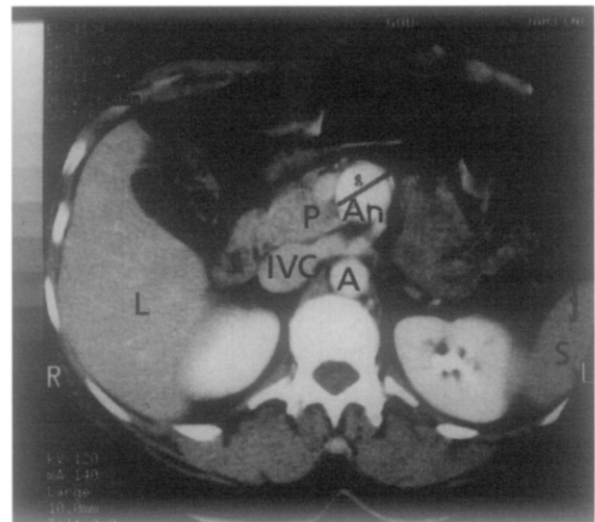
Case 2. Transverse CT scan shows location of aneurysm behind pancreatic body. *L*, Liver; *S*, spleen; *P*, pancreas; *A*, aorta; *IVC*, inferior vena cava; *An*, aneurysm.
